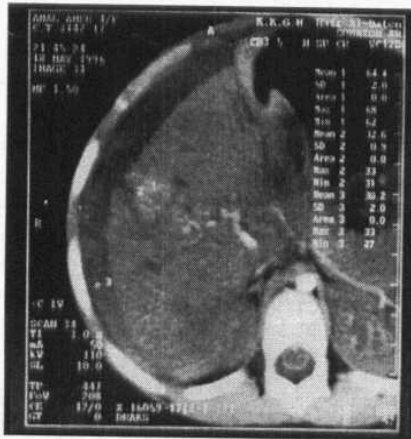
CT Scan showed a bilobar fracture with parenchymal collection and haemoperitoneum.
